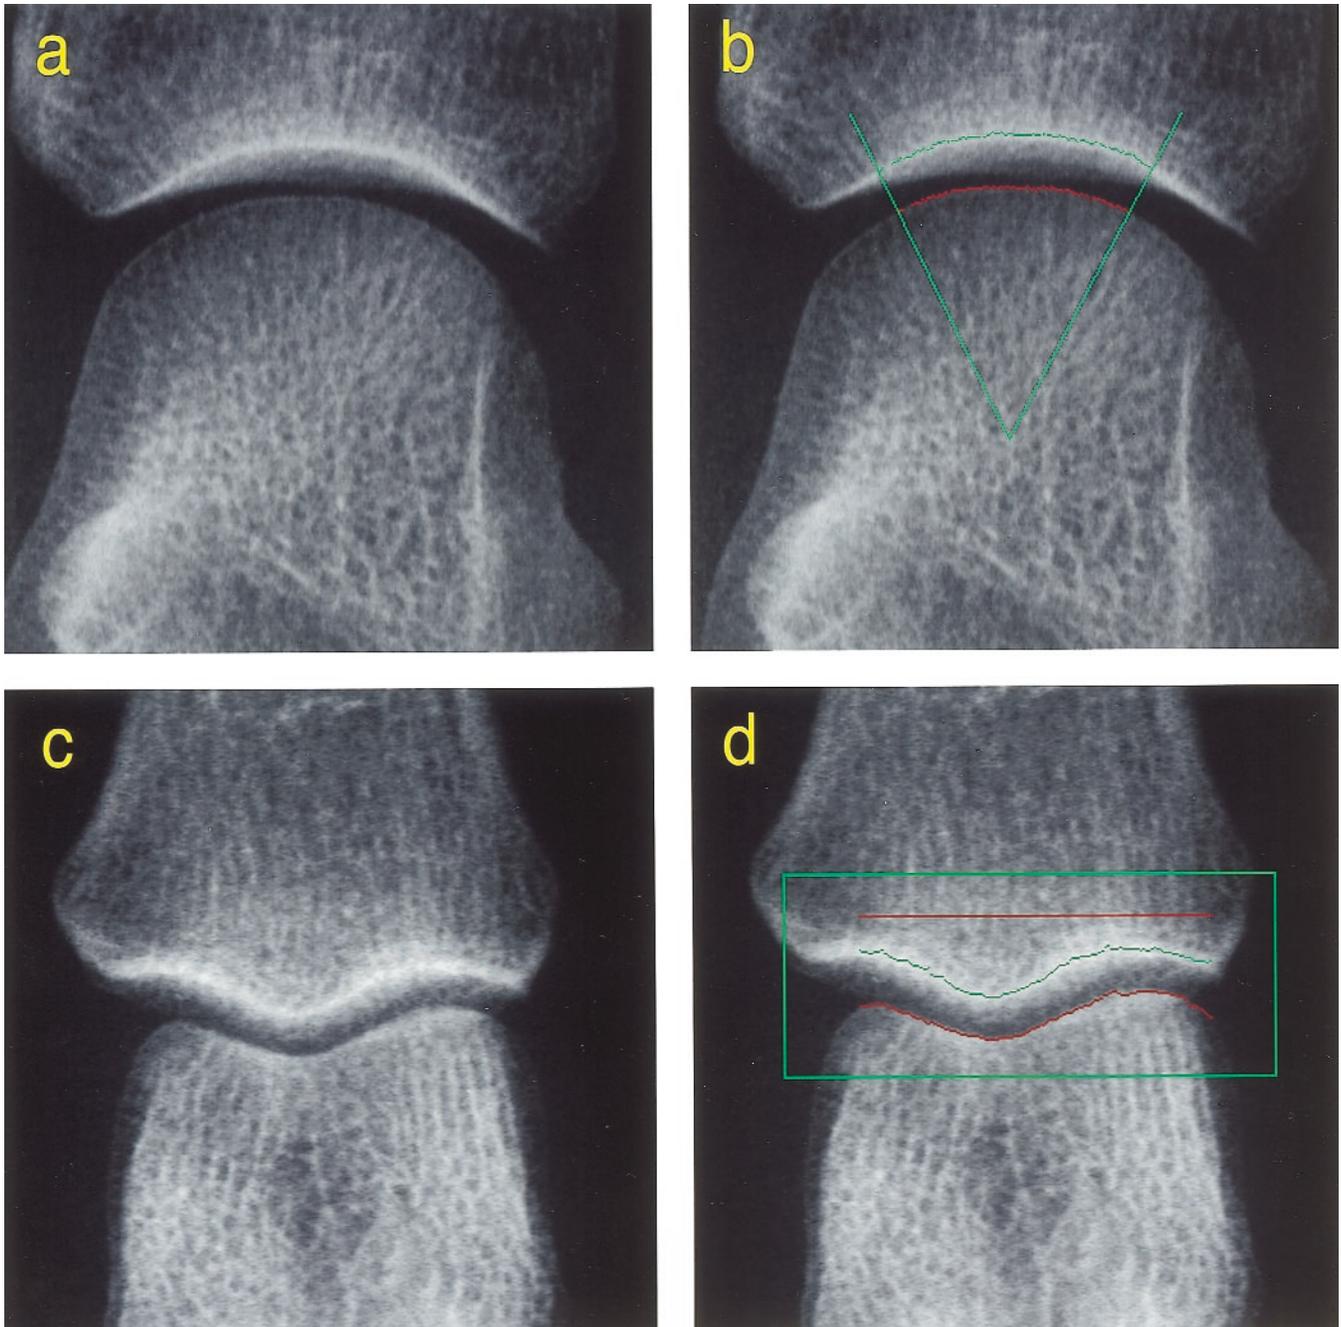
Anatomical landmarks used for computerized mean JSW measurement in MCP and PIP radiographs: (A, C) unprocessed radiographs; (B, D) processed images showing detection of the proximal (red) and distal (green) joint margins. The green sector in (B) identifies the 1-radian sector of MCP joint used to determine mean JSW. The rectangular box in (D) is input by the user to roughly locate the PIP joint. The horizontal red line corresponds to accepted valid measurements across the PIP joint.
